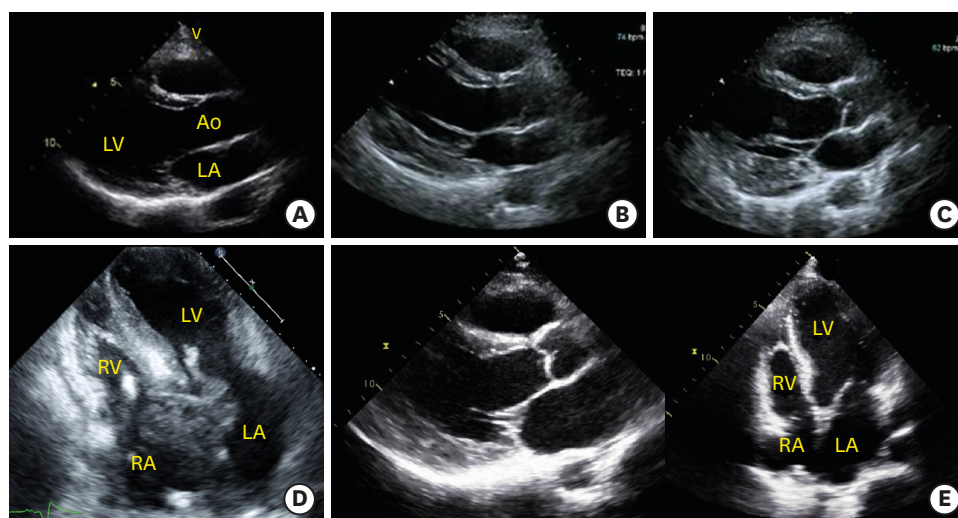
Images of transthoracic echocardiography. (A) Transthoracic echocardiogram at the time of the first hospital visit showed normal findings. (B) In the 4th year after the first visit, it indicated hypertrophied posterior wall thickness with hyperechoic myocardium. (C) In the 5th year after the first visit, unusual pattern of LV inferolateral wall hypertrophy was shown. (D) In the 7th year after the first visit, more progression of asymmetric LV hypertrophy and a huge mass in RA cavity with near-total obstruction of flow across tricuspid valve were observed. (E) Nine months after chemotherapy, the huge mass involving interatrial septum disappeared and LV wall thickness was nearly normalized.
